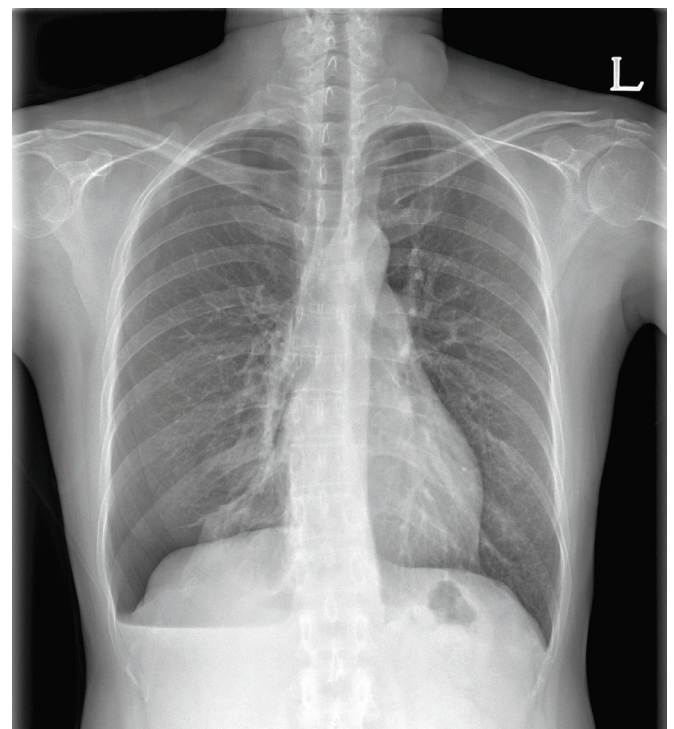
Chest X-ray revealed right pneumothorax.
